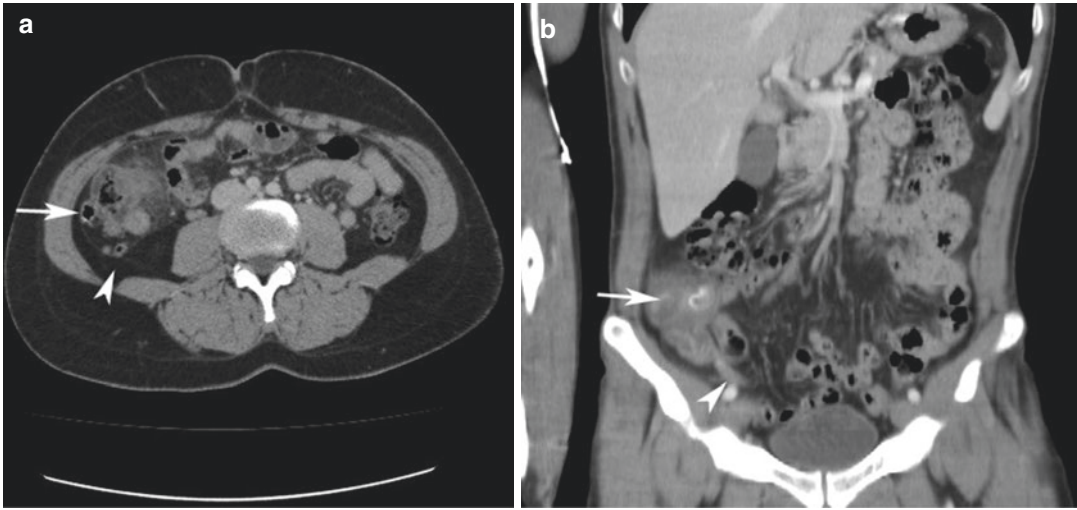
Normal (a) and complicated (b) cecum diverticulum (arrow) and normal appendix (arrowhead) are seen in two different patients' abdominal CT images
